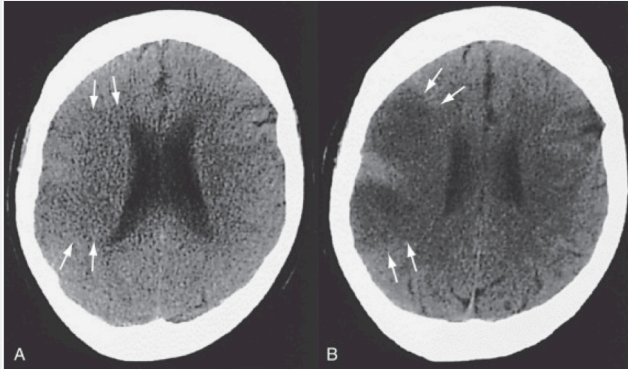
CT scan taken 3hrs after a large right MCA occlusion. Subtle, early ischemic changes include loss of the gray-white interface and sulcal effacement.
